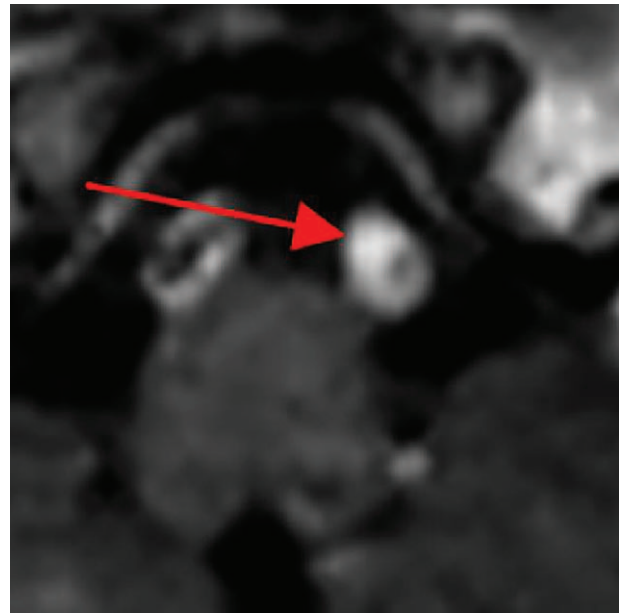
An unstable plaque at the stenosis site (magnetic resonance imaging; July 11, 2015).
